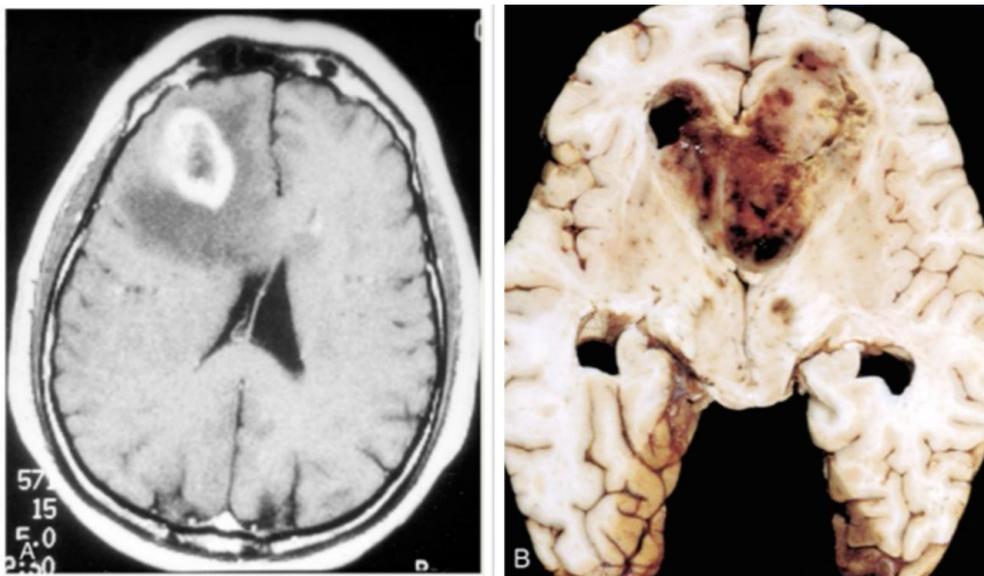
Figure A shows a computed tomographic (CT) scan with contrast of a large tumor in the cerebral hemisphere of the brain. Figure B shows a necrotic, hemorrhagic, infiltrating mass of tumor in the brain (“Section IV: Biological Factors Contributing to Pathophysiology”, p.566).
